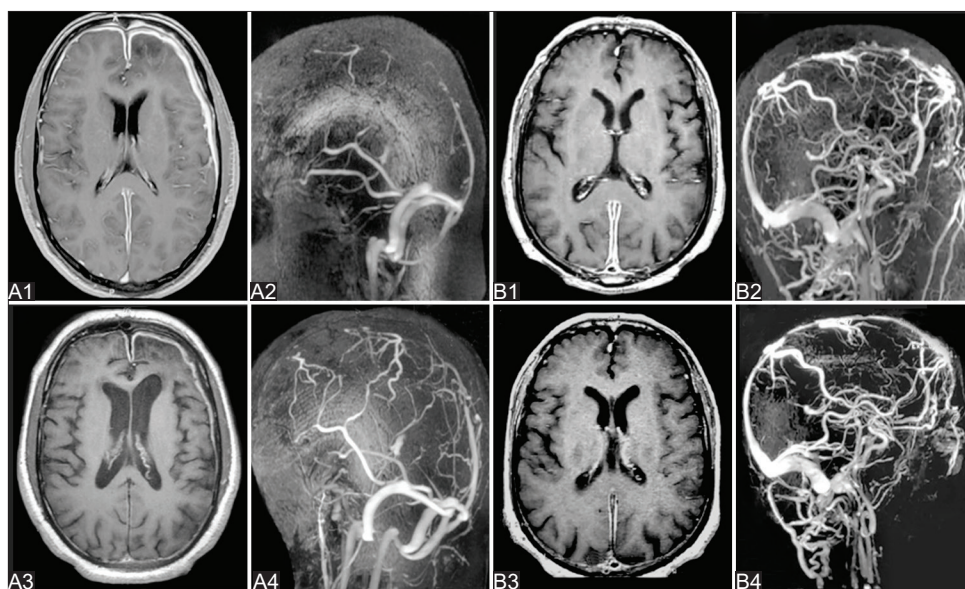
T1 contrast MRI and MR venography in two patients with IgG4-related disease. MRI of patient # 1 show (A1) hypertrophic pachymeningitis in falx cerebri and left side hemisphere at baseline which only partially resolved at 3-month follow up (A3). MR venography of the same patient at base line (A2) shows superior sagittal sinus (SSS) and straight sinus thrombosis which remained occluded at 3-month follow up (A4). MRI of the patient # 2 also shows pachymeningitis (B1) which resolved partially at 3-month follow up (B3). MRV of the same patient shows thrombosis of straight sinus and SSS (B2) which remained occluded at follow up except partially recanalized SSS (B4)
